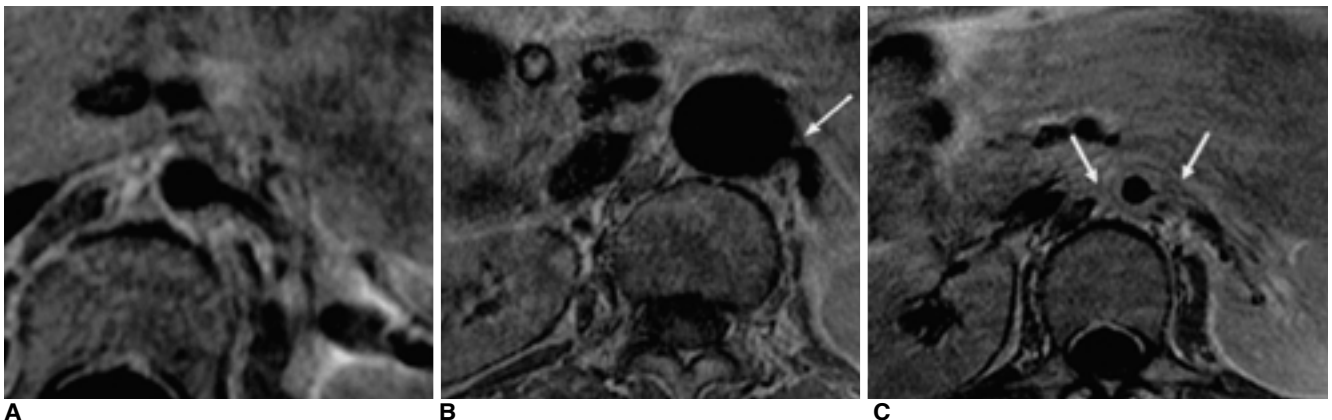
Varying degrees of renal arterial involvement are shown by contrast-enhanced spin echo T1-weighted images.
